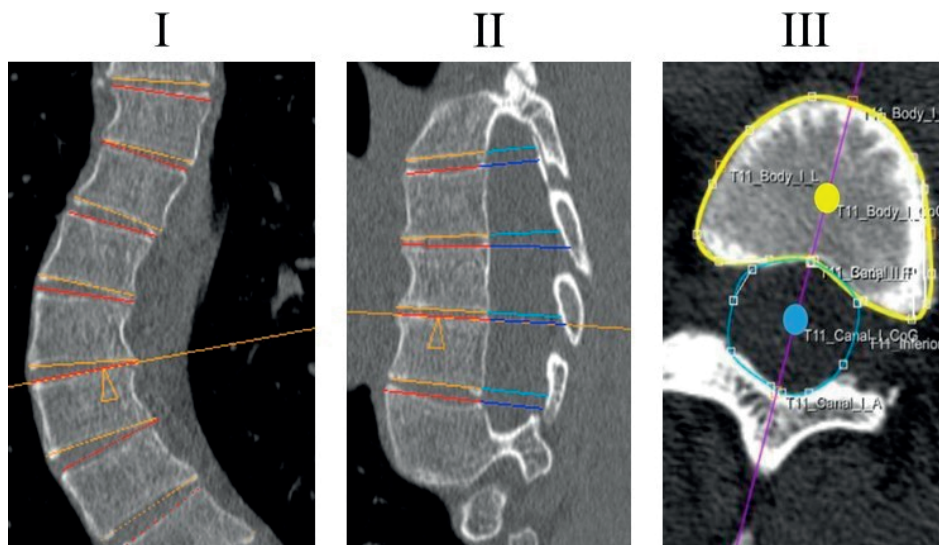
The orientation of the upper and lower endplate of each individual vertebra of the computed tomography scans was determined by using the semi-automatic software, correcting for coronal (I) and sagittal (II) tilt, to reconstruct true transverse sections. The observer drew a contour around the vertebral body (yellow line in III) and spinal canal (blue line in III). The semi-automatic software calculated a center of gravity of the vertebral body (yellow dot in III) and spinal canal (blue dot in III). For each endplate, its longitudinal axis was calculated as the line between those two points (purple line in III).
